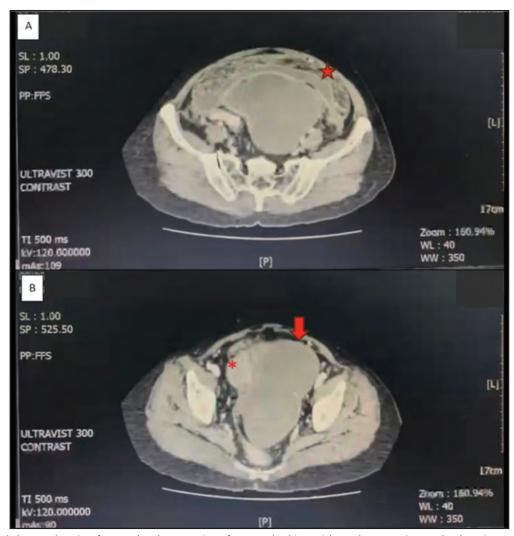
A: CT of abdomen showing feature (star) suggestive of omental caking with moderate ascites and enhancing peritoneal nodules.
